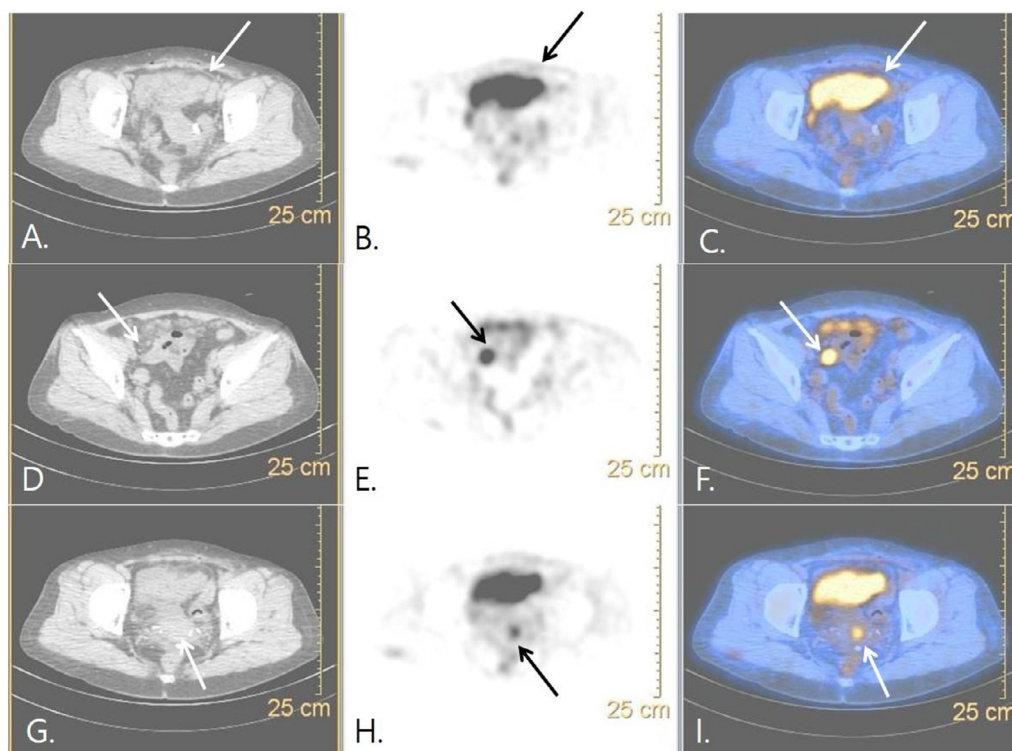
No soft tissue mass was observed in the pelvic cavity omentum when compared with CT images taken in April 2016.
